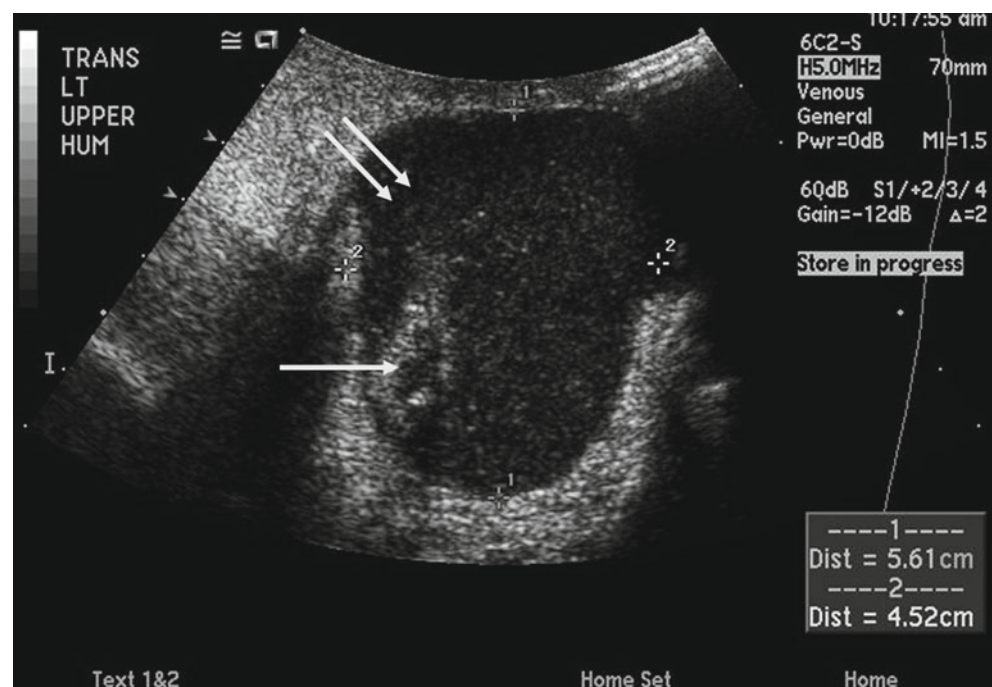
Ultrasound of prosthetic graft identifies the graft (single arrow) within a large pocket of fluid with heterogeneous material (double arrow) indicating infection
